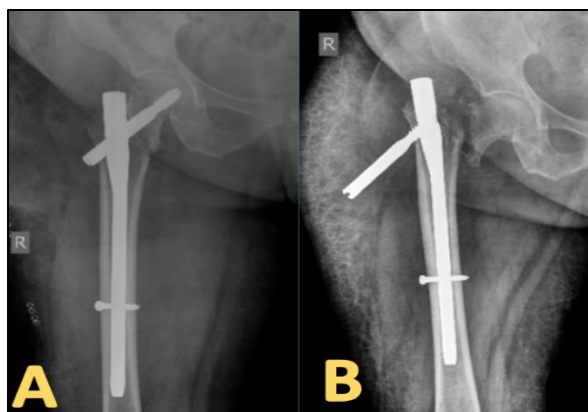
(A) Radiograph of patient with complication of screw back out leading to fracture displacement and non-union. Immediate post-operative X-ray and (B) screw back out and fracture displacement.
